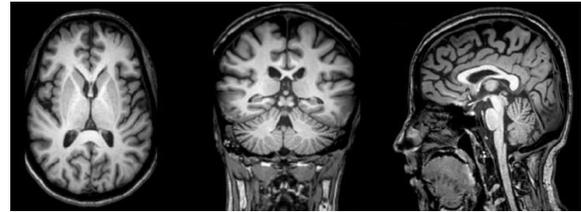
MRI planes for MRI head scan (a) Axial (b) Coronal (c) Sagittal
